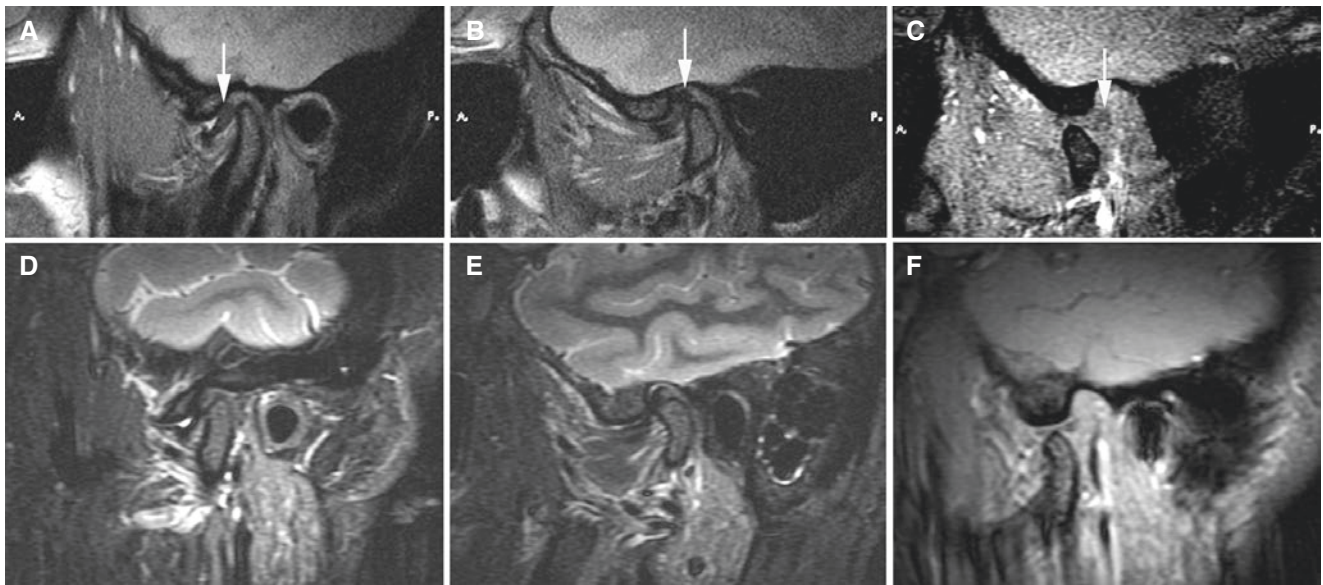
Partial disc displacement (disc displaced only in one part of the joint) with reduction, normal bone; 39-year-old female (A, B, C). (A) Oblique sagittal T2-weighted MRI shows small amount of fluid and disc displacement; posterior band (*arrow*) located in anterior position to the condyle in one section. (B) Oblique sagittal T2-weighted MRI
